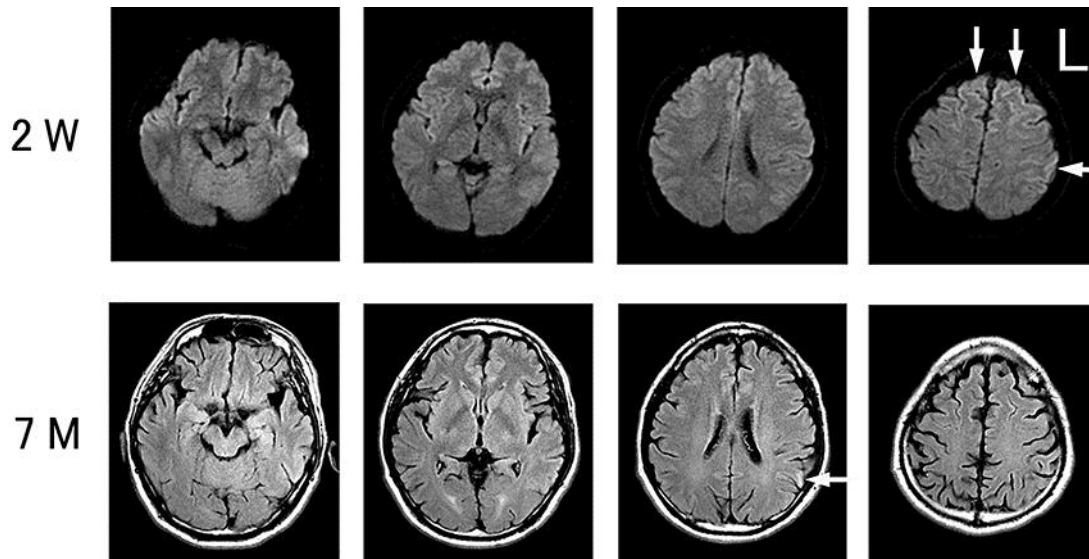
MRI 2 weeks after onset (2 W) and 7 months later (7 M). Diffusion-weighted axial imaging performed 2 weeks after onset (upper panels) revealed hyperintensity in the bilateral frontal and left parietal cortices (arrows). Fluid-attenuated inversion recovery axial images obtained 7 months after onset (lower panels) revealed a high signal intensity in a small area of the left parietal cortex (arrow).
